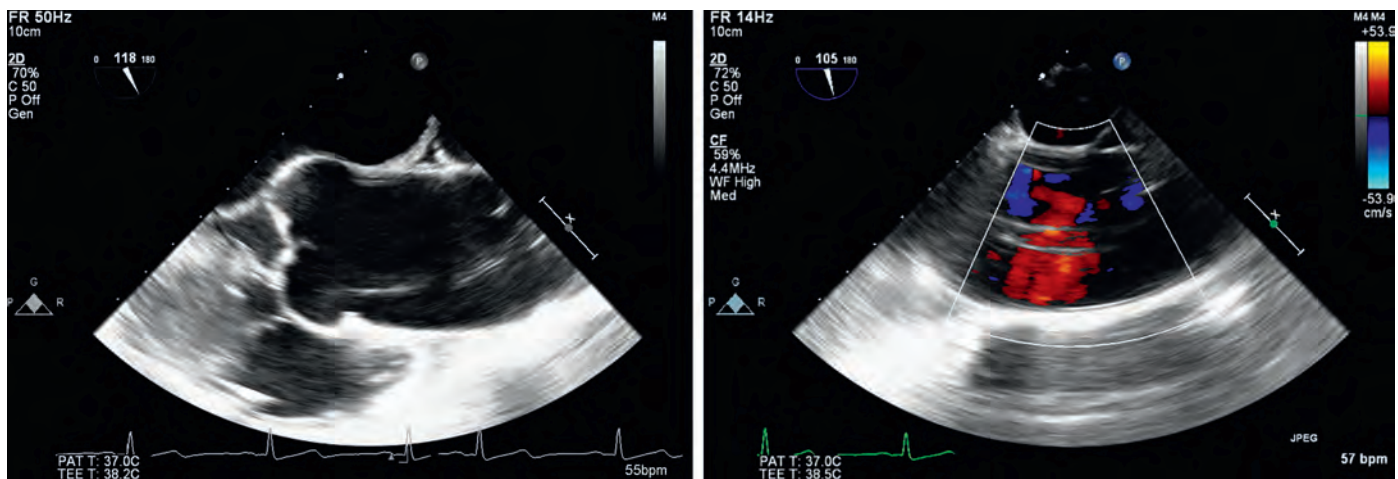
Linear reverberation artifact. Midesophageal ascending aortic long-axis view. A linear reverberation artifact is seen in the ascending aorta. Color-flow Doppler does not demonstrate any effect of the artifact on blood flow patterns.
